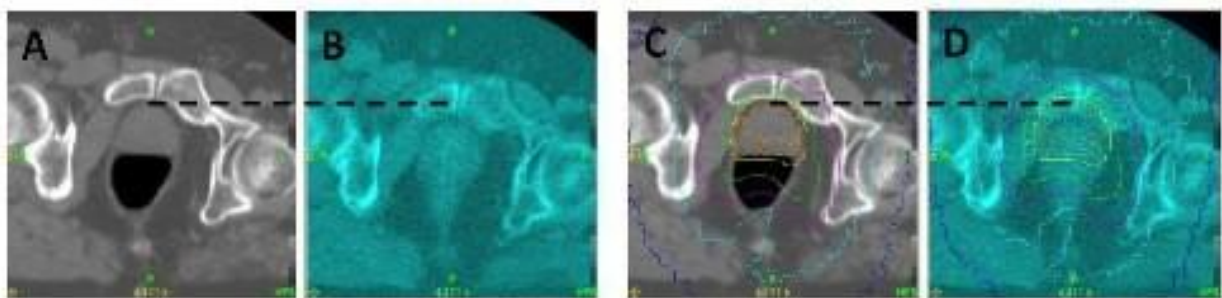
Planning CT (A) compared to daily Tomo MVCT (B). The patient is more posterior on the treatment machine MVCT, and the rectum an entirely different shape. (C) shows the intended dose, and in (D) the dose overlay shows that dose to both target and rectum would be substantially lower. In this case, the position was corrected before treatment to deliver the dose correctly to the target. Without IGRT, rectal dose would have been lower than planned; after IGRT correcting target position, the rectal dose would have been higher. However, in both scenarios the distribution of dose to the rectum is entirely different from that planned.
